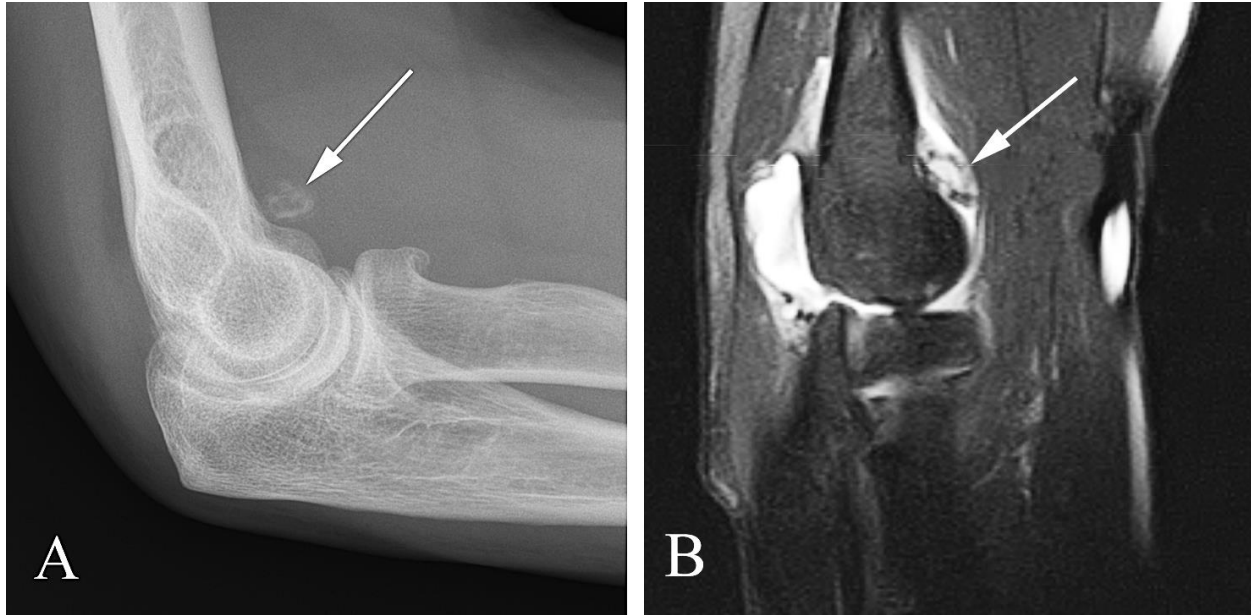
Loose body in the elbow joint in a 54 year old man with elbow pain. A. Lateral plain film shows an osseous fragment (arrow) projecting anterior to the distal humerus. B. Sagittal fat suppressed T2 weighted image demonstrates a joint effusion and the osseous fragment surrounded by elbow joint effusion fluid (arrow).
